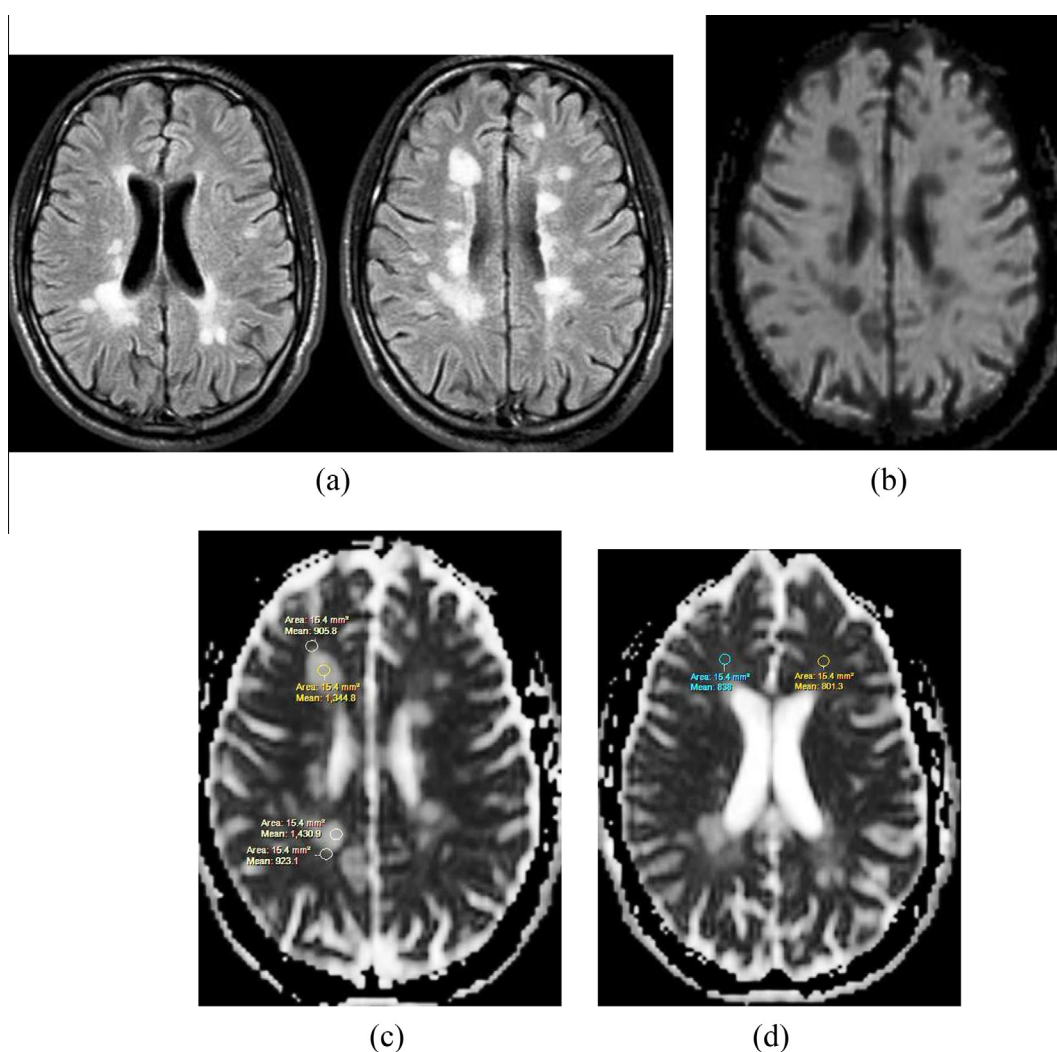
38 year old female patient with RRMS and no relapse for 11 months with mild cognitive impairment (MOCA score 23). (a) Axial FLAIR showed multiple plaques, (b) DWI image showed signal intensity of facilitated diffusion, (c) ADC map showed the following readings: Plaque 1.4309×10^{-3} , Periplaque 0.9231×10^{-3} and NAWM in image, (d) were 0.838×10^{-3} & $0.8013 \times 10^{-3} \text{ mm}^2/\text{s}$.
